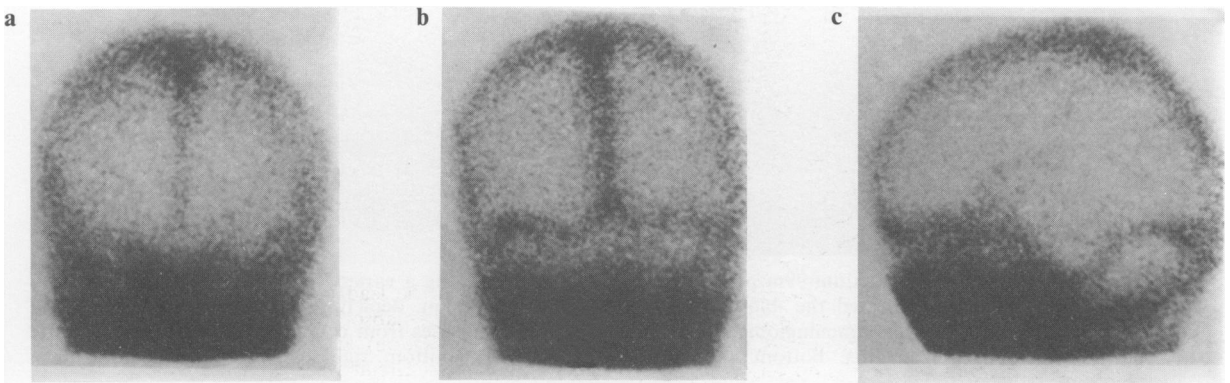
Normal planar scintigrams of the head using technetium-99m as pertechnetate: anterior (a) posterior (b) and a lateral (c). Most of the activity is in the venous sinuses and the soft tissues of the head. The normal brain is relatively free of activity. High activity blackens X-ray film, but appears white on polaroid film. (From *Clinical Nuclear Medicine*, Eds Maisey, Britton and Gilday, London, Chapman & Hall. Reproduced with permission.)
